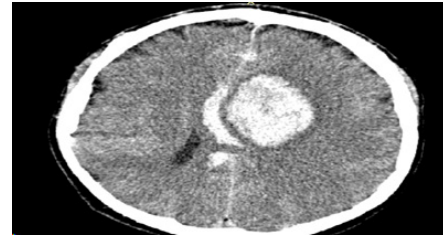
CT scan revealed an enlargement of the intraparenchymal hemorrhage with ventricular effusion.
